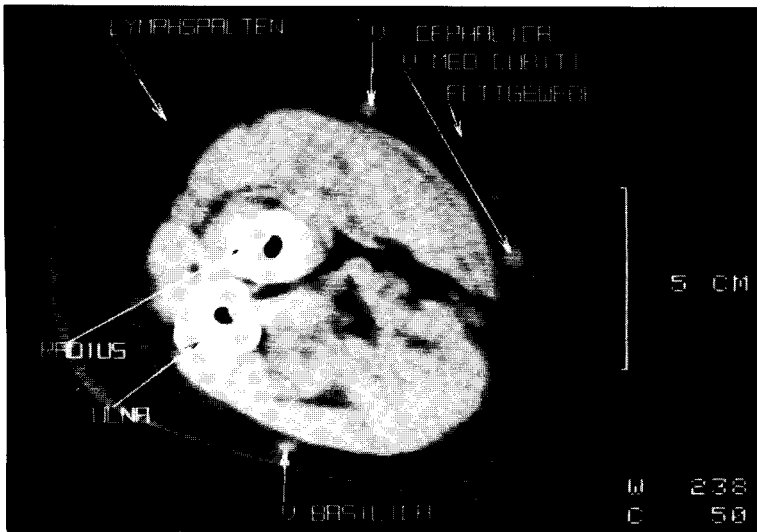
Computed tomography of forearm in patient with severe lymphedema after modified radical mastectomy and post-operative irradiation. Note the thickened skin and distention of lymphatics in ring-like patterns and honeycomb formation.
